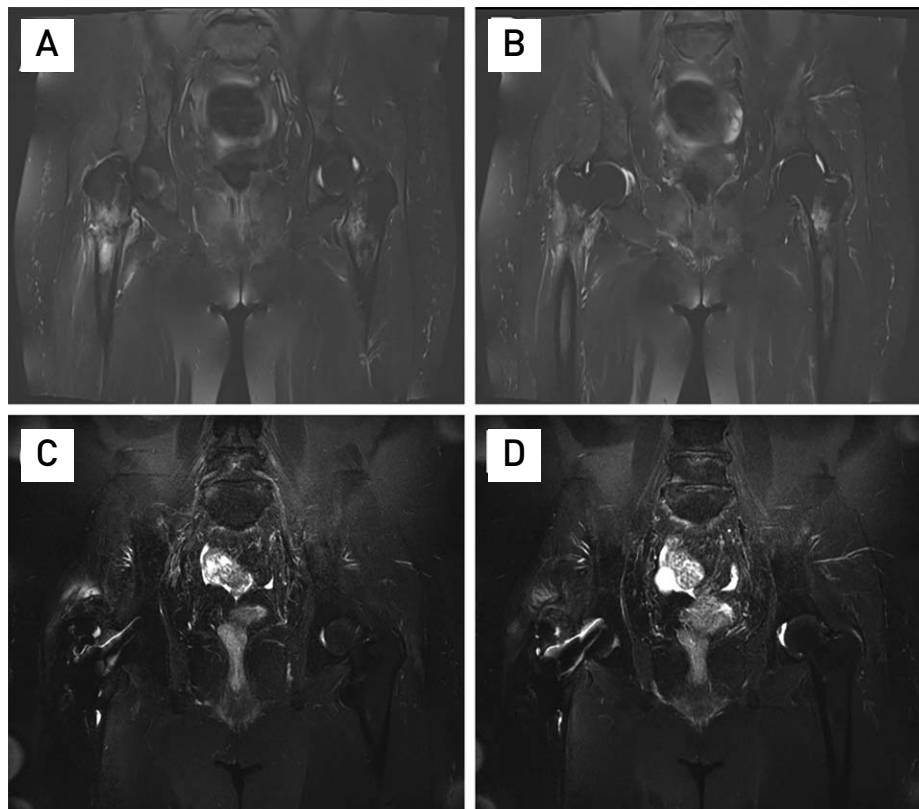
(A, B) A magnetic resonance imaging (MRI) T2-weighted sequence of the pelvic area showed a right proximal femur fracture with a perilesional soft tissue injury, a suspicious focal bone lesion in the subtrochanteric area, and an incomplete fracture in the left proximal femur in the same subtrochanteric area. (C, D) Seven months later, X-ray and MRI were performed to evaluate the insufficiency fracture of the left femur. An MRI T2-weighted sequence of the pelvic area showed the incomplete fracture in the left proximal femur with healing of the perilesional soft tissue injury and disappearance of the signal change in the bone marrow and lesser trochanter of the proximal femur.
